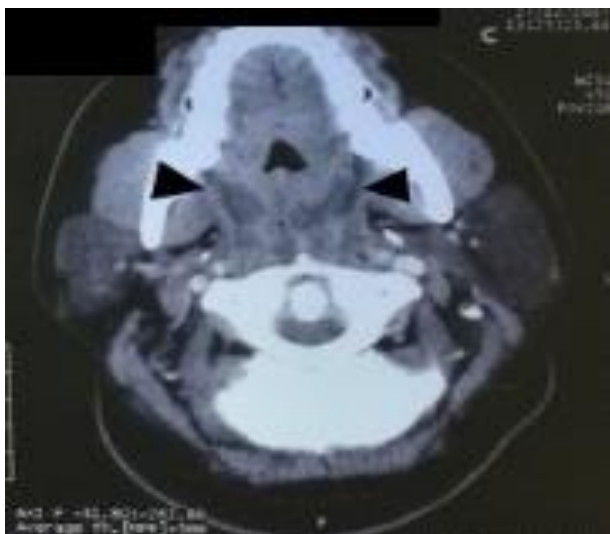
Contrast-enhanced computed tomography of neck, at level of oropharynx, axial view.
